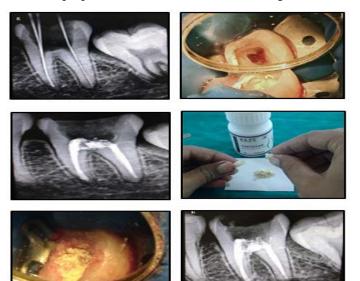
(a) Initial periradicular radiograph of a mandibular left second molar showing a large furcal perforation and apical radiolucencies in the patient; (b) Intraoral photograph showing root canal and a large furcal perforation; (c) periradicular radiograph of a mandibular left second molar showing obturated root canal; (d) Dispensing of chitosan powder after opening of capsule; (e) use of cement carrier for placing chitosan into the pulp chamber; (f) intraoral picture of Chitosan being placed into the furcal perforation; (g) Radiograph of chitosan being placed in to the furcal perforation.
